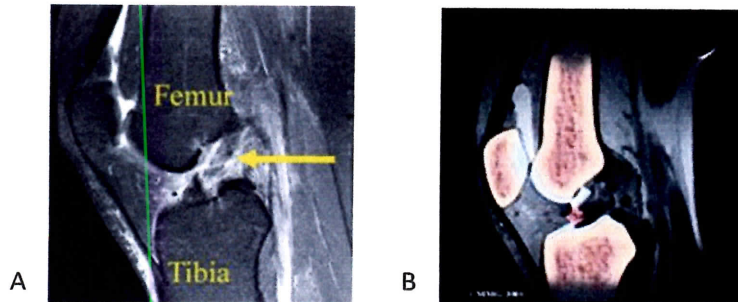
MRI of torn ACL shown with (A) an arrow and (24) (B) artistic enhancement (6)
